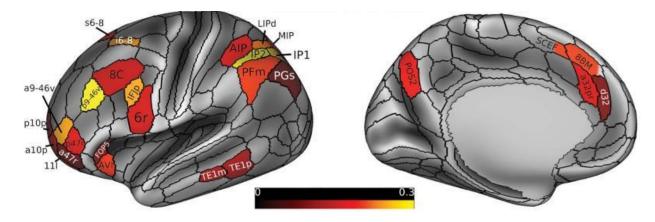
The 'Extended' multiple-demand (MD) system represented by non-grey brain regions. This figured is based on functional MRI and reproduced from Assem et al., 2020 with permission.
